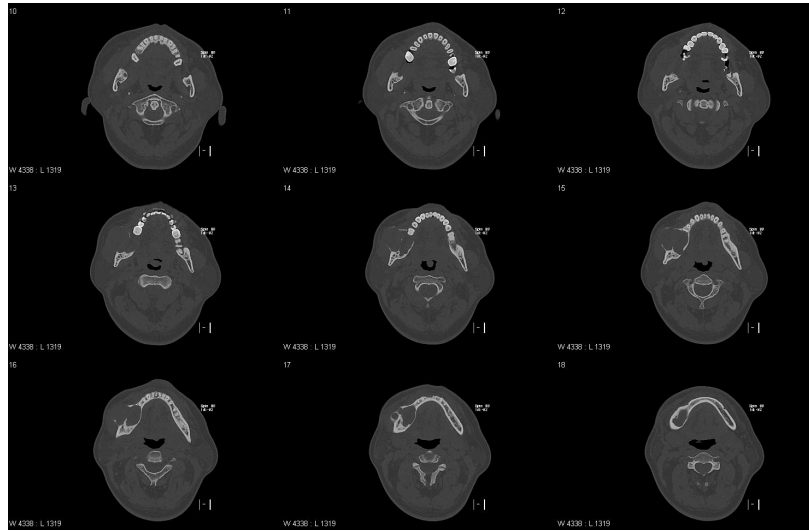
Mandible CT images
